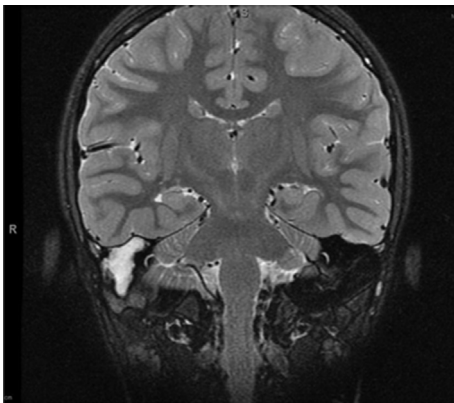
T2-weighted coronal MRI with contrast showing right-sided hyperintense mass.
